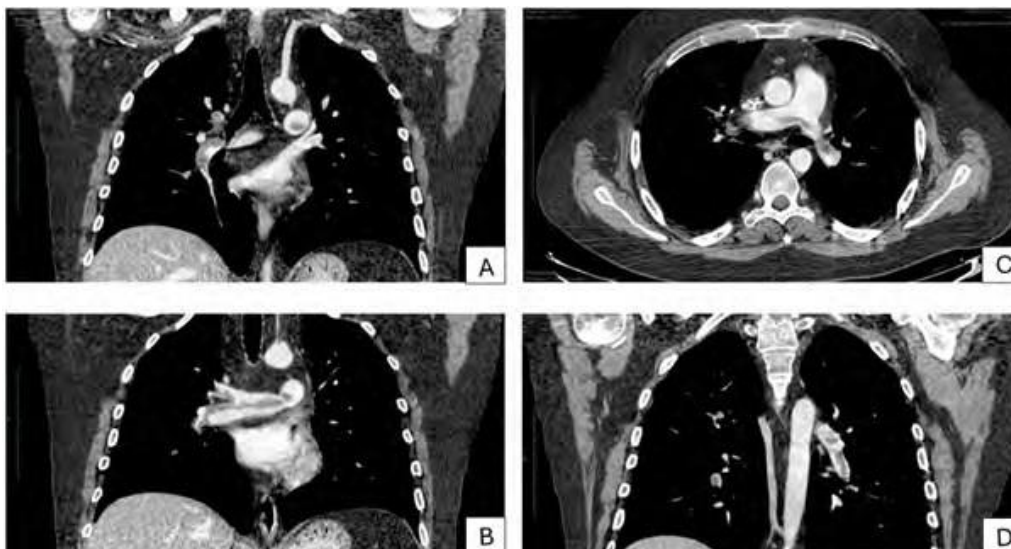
Pulmonary angio-CT in axial plane (C) and coronal reconstruction (A, B, D) sections demonstrate the extensive central and peripheral pulmonary thromboembolism as a filling defect at the pulmonary trunk bifurcation, extending bilaterally in the main pulmonary arteries and the segmental lobar arteries.
